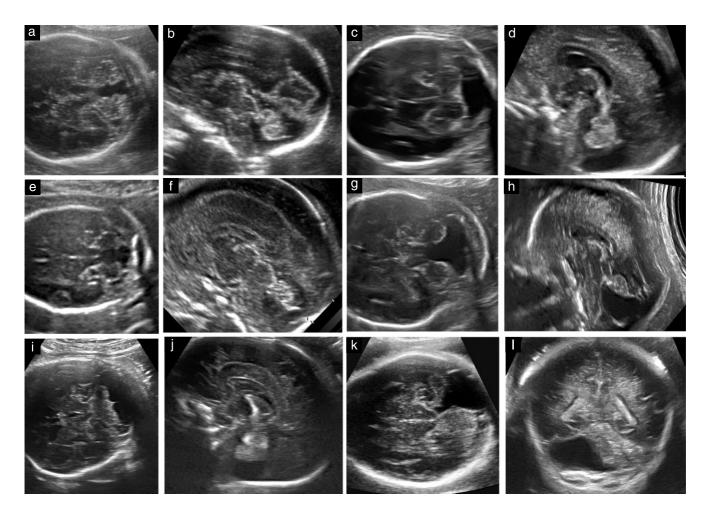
Categorization of posterior fossa fluid collections on ultrasound: (a,b) Blake's pouch cyst; (c,d) megacisterna magna; (e,f) vermian hypoplasia; (g,h) Dandy–Walker malformation; (i,j) cerebellar hypoplasia; (k,l) arachnoid cyst of the posterior fossa.
